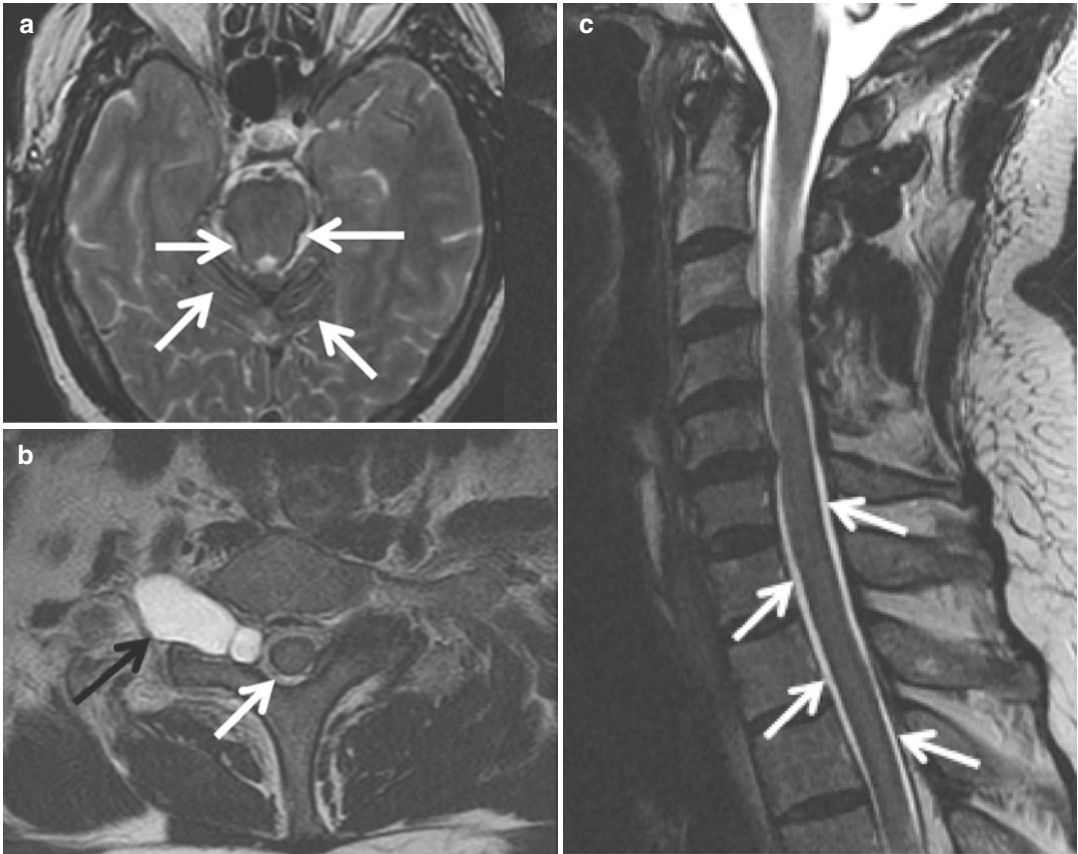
Superficial siderosis as a chronic phase complication of traumatic preganglionic brachial plexus injury. T2-weighted axial brain (a) and axial (b) and sagittal (c) cervical spine MR images obtained 40 years after trauma. The pial surface of the brain and spinal cord is
